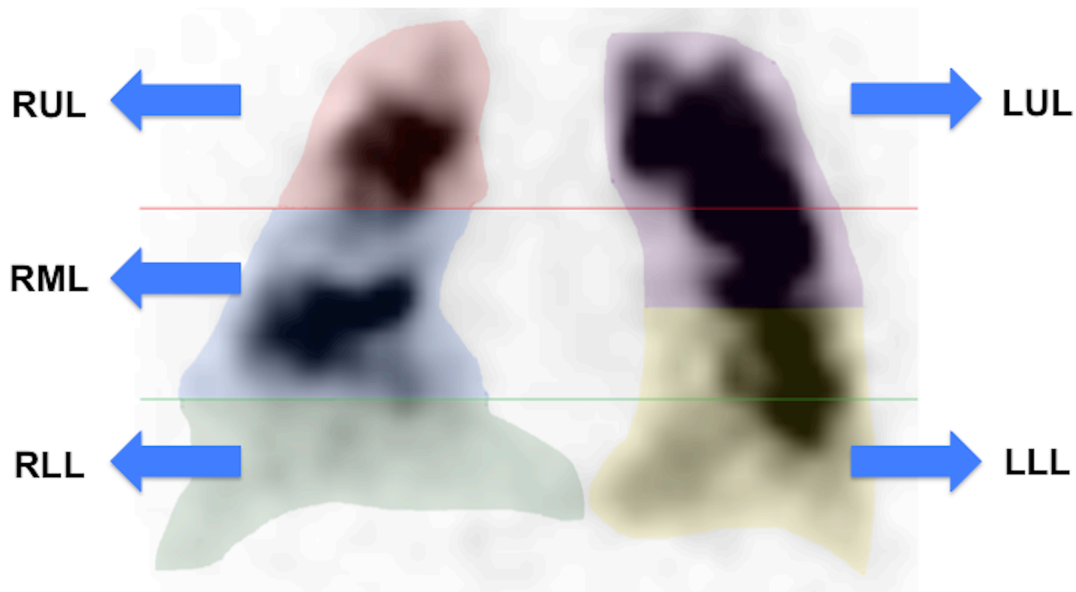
The 2-D method for regional analysis of planar perfusion scintigraphy. The lung is divided into five regions-of-interest (ROIs) without any reference to anatomic landmarks. The relative perfusion contribution of each coloured ROI is considered representative of the different lobes of the lung and is used to predict the effect of lobar resection.
